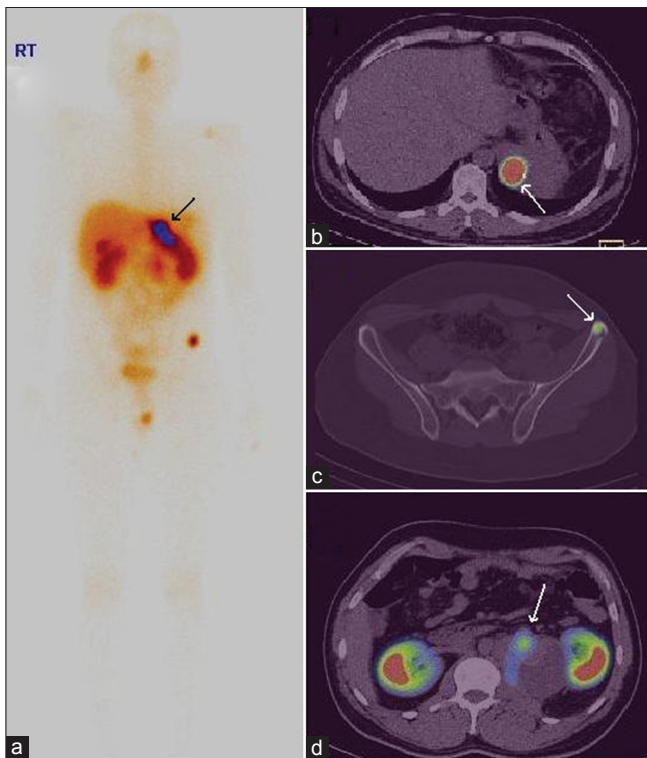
Whole body lutetium-177 DOTATATE (a) and single photon emission computed tomography/computed tomography images showing intense uptake in the deposits (b) and left ilium (c), mild uptake in the paraaortic lymph nodes (d) (arrows)
